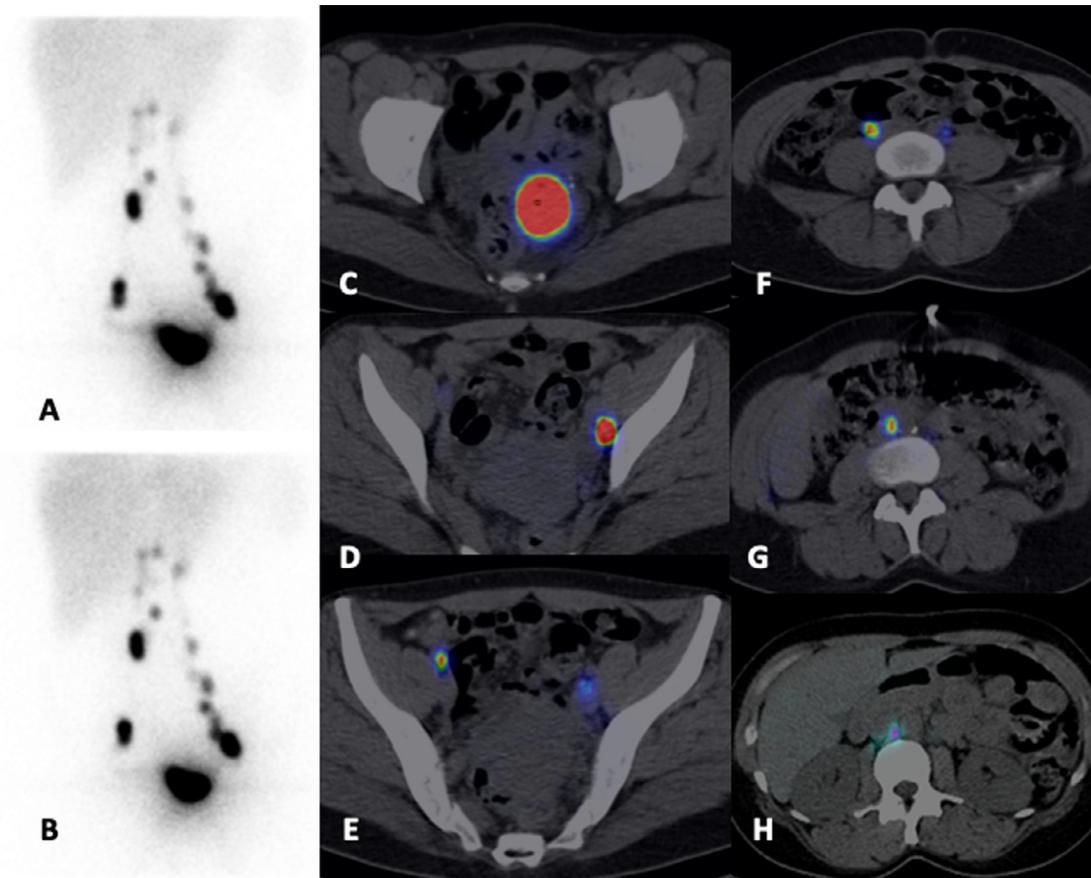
A 37-year-old woman with a FIGO IA endometrioid adenocarcinoma underwent sentinel lymph node scintigraphy. After four injections of about 40 MBq each, several focal uptakes were observed in planar acquisitions at 10 and 60 minutes (A and B). The fused SPECT/CT views showed the cervical injection site (C) and bilateral lymph node drainage with iliac external lymph node uptake (D and E). All nodes showed no metastatic spread.
